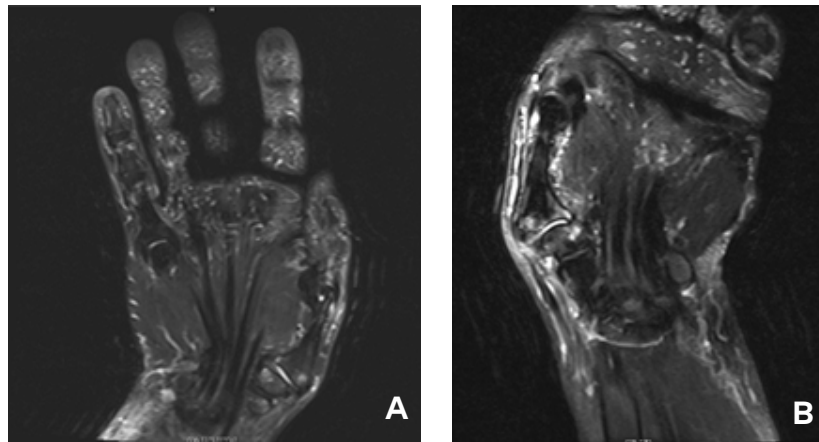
A) MRI T2 coronal of the left wrist showing severe hypertrophic change present in the first CMC joint space, B) MRI T2 coronal of the right wrist showing severe hypertrophic changes present in the first CMC joint space with superimposed erosive disease.
